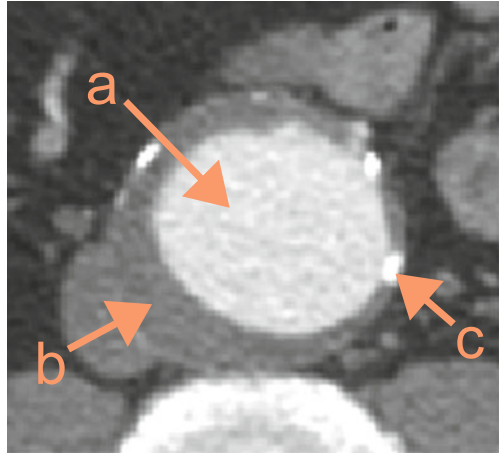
CTA image variability makes thrombus segmentation challenging. (a) Outer thrombus surface not visible. (b) Similar CT intensities between the thrombus and other tissues. (c) Irregular thrombus geometry. (d) Strong intensity gradients near the spine, the heart, and the lungs [46]
